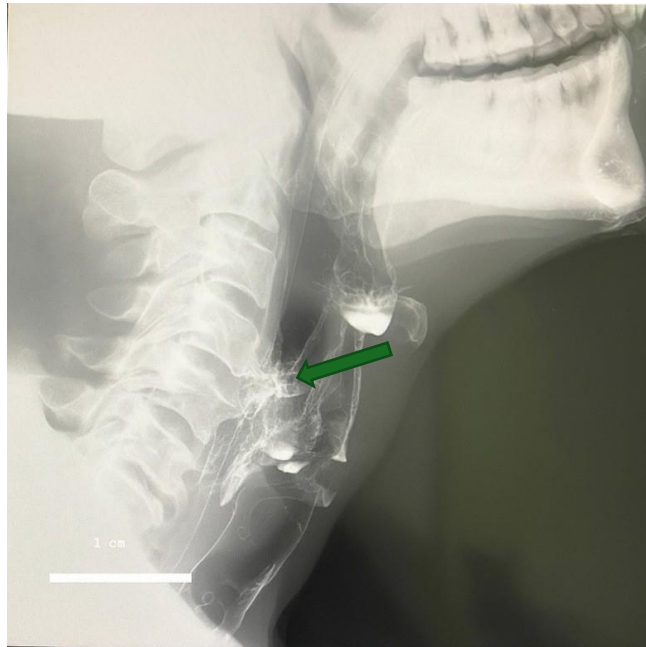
A lateral neck x-ray showed a prominent anterior cervical osteophyte on the C5 vertebra
